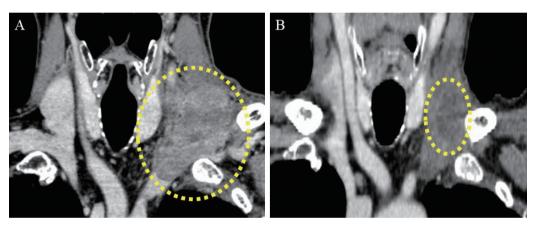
(A) CT revealed an irregular-shaped tumor in the left supraclavicular region with infiltration of the internal carotid artery. (B) Chemoradiotherapy markedly reduced the size of the lymph node recurrence.
